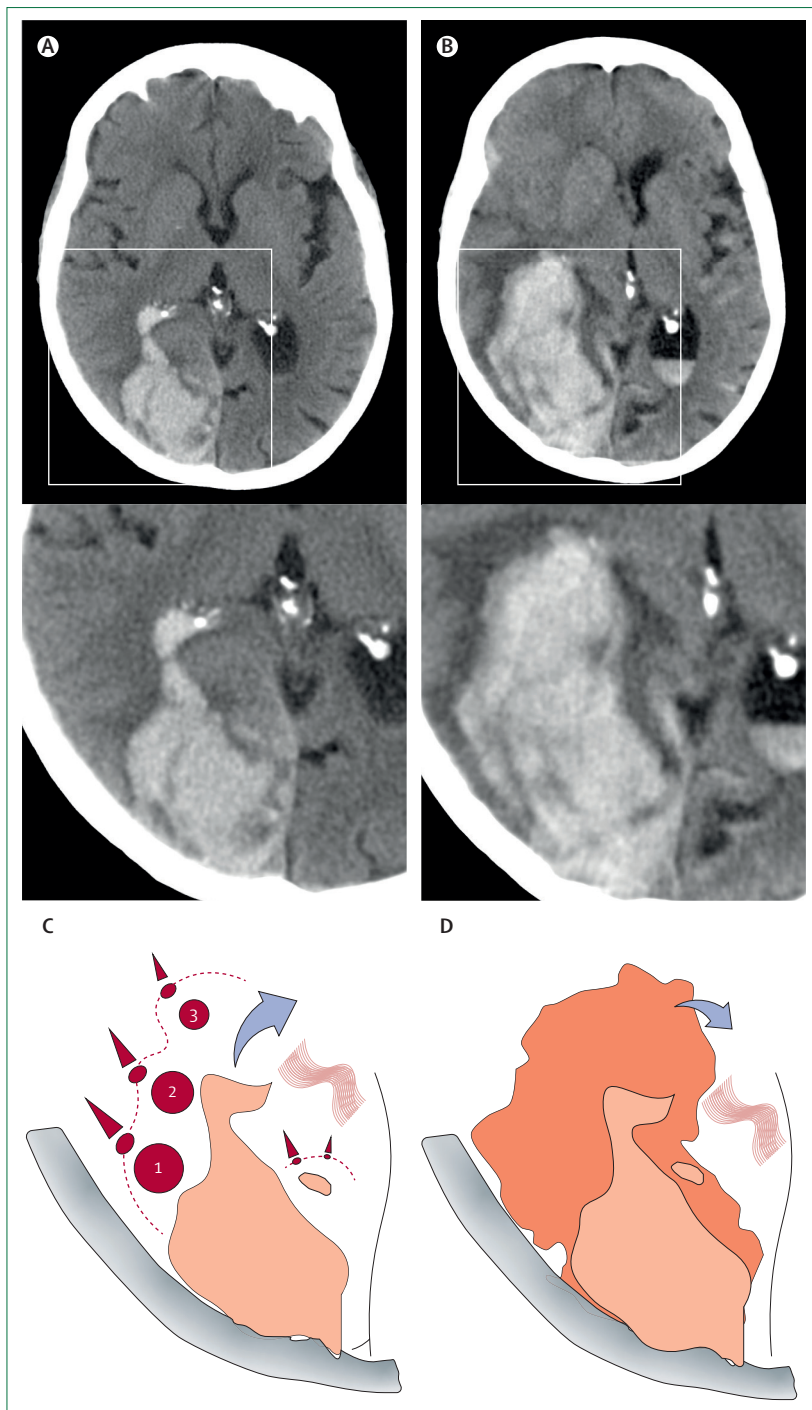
Baseline and follow-up non-contrast CT with haematoma expansion
